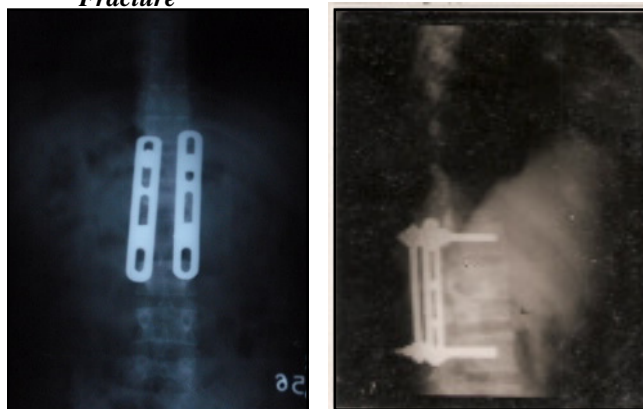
Postoperative AP and Lateral X-ray Showing Steffee Plating
